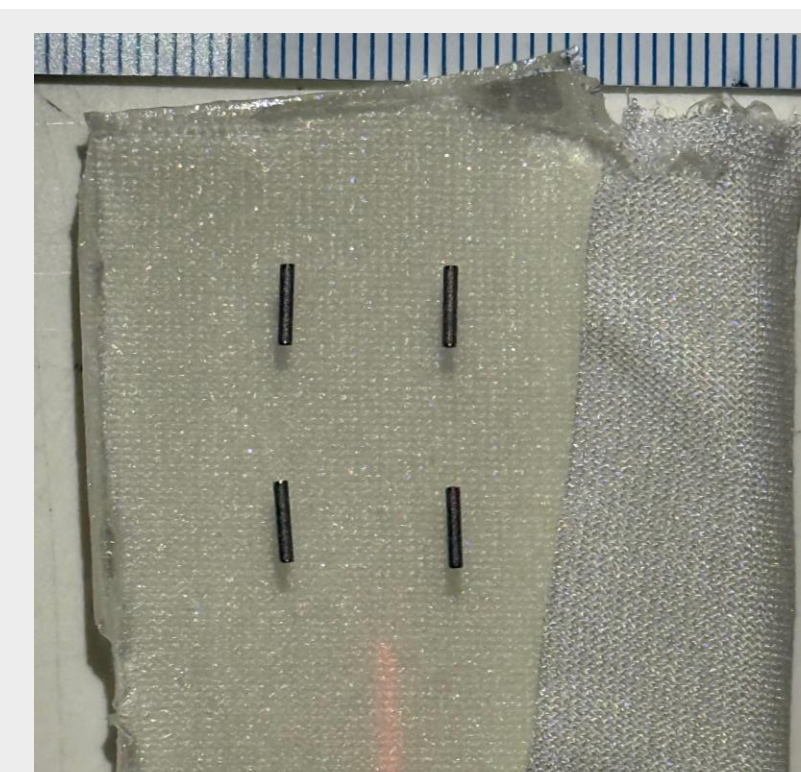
Seed configuration used in CT dataset 1 in bolus
